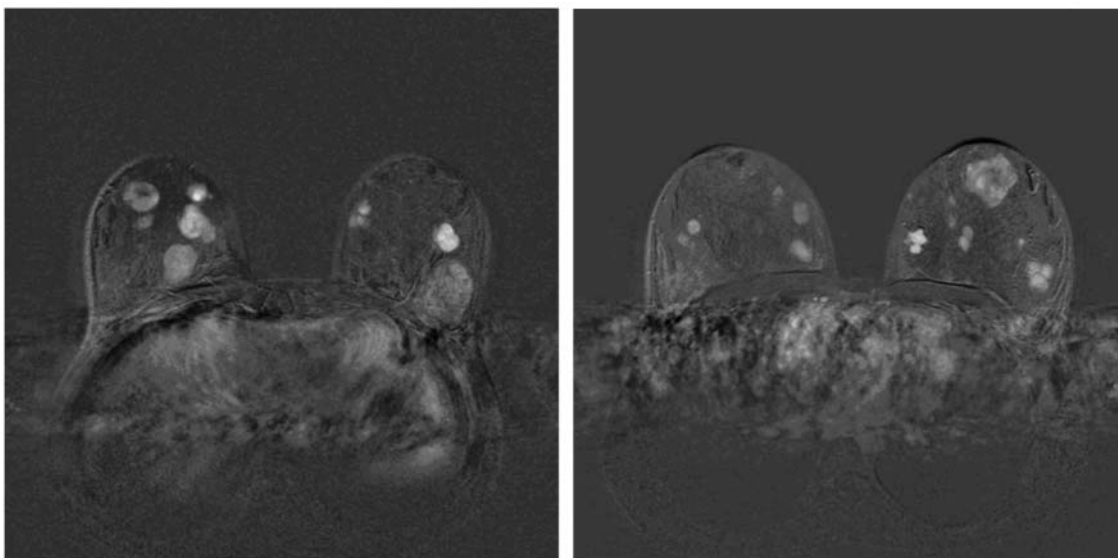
MRI slides of fibroadenomas of different sizes in one patient.
